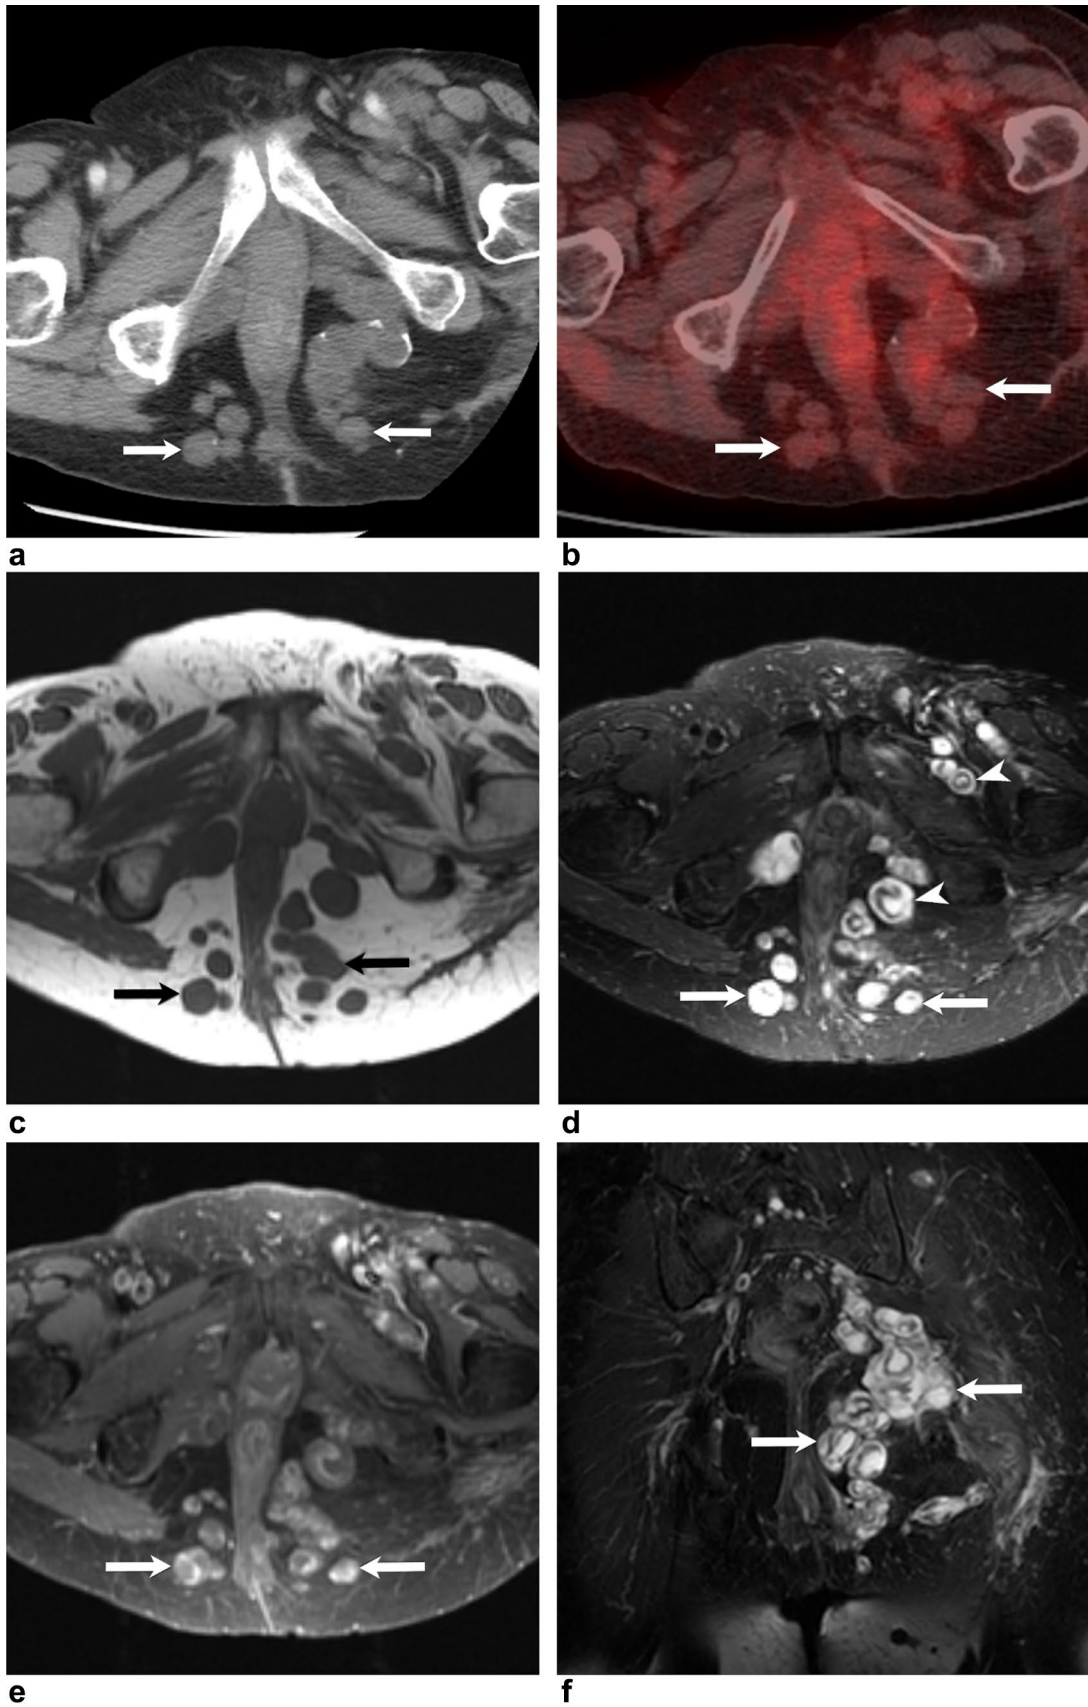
65-year-old female with neurofibromatosis. a, b Axial CT image (a) showing multiple hypodense soft tissue nodules (arrows), some partially calcified, within the bilateral ischiorectal fossae that do not show FDG uptake on the PET/CT image (b). c–e Pelvic MRI, Axial T1WI (c), T2WI (d) show multiple T1-hypointense and T2-hyperintense soft tissue nodules of varying sizes (arrows) within the bilateral ischiorectal fossae. d Some nodules presents the target-like appearance with a central low signal and peripheral high signal intensity (arrowhead) and enhancement on the post-contrast T1WI image (e). f Pelvic MRI, Coronal T2WI shows the multiple neurofibromas
